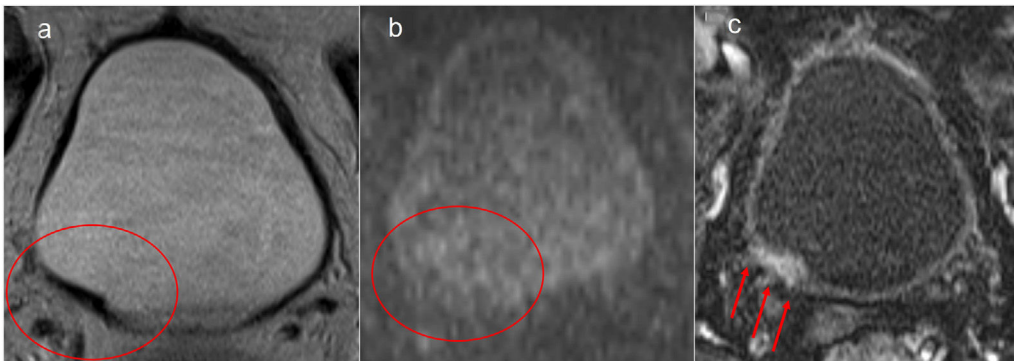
Patient with a history of TUR performed 40 weeks earlier with an outcome of pT1 with suspected local recurrence on control cystoscopy in the posterior wall (segment 5). a) Axial T2. b) Diffusion (b1000). Hypointense thickening in T2 of the posterior wall of the bladder (red circle) with no diffusion restriction in the bladder wall and no suspicious lesion on the T2-weighted sequence. c) Dynamic early phase contrast-enhanced study. Significant contrast enhancement at the site of the prior TUR extending into the muscle layer (red arrows). A subsequent TUR revealed fibrosis and chronic inflammatory changes, with no signs of tumour recurrence.
